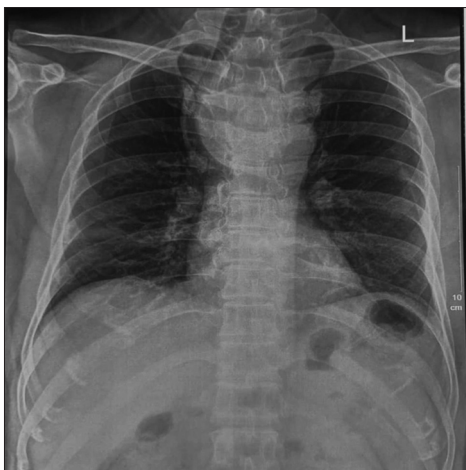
Posteroanterior chest radiograph showing a broad-based mediastinal opacity at the thoracic inlet with tracheal deviation to the right
